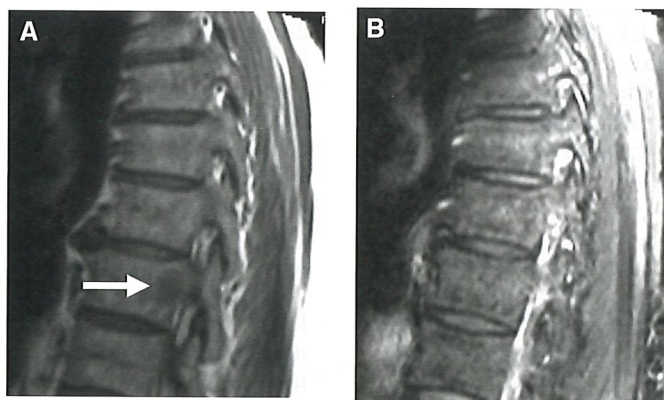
Nodule of red marrow. (A) Sagittal T1-weighted and (B) fat-saturated intermediate-weighted FSE images of the thoracic spine of a 73-year-old man with lung cancer show an area of slight decrease in signal intensity (arrow). The signal of the lesion is similar to that of the intervertebral disk. Biopsy of another similar (larger) lesion in the same patient demonstrated normal but hypercellular marrow.
